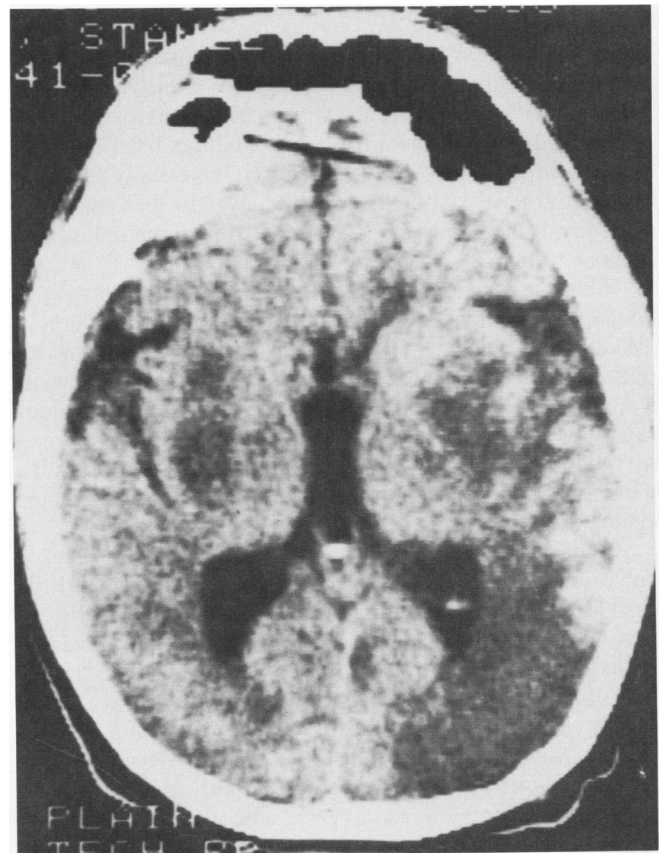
A final computed tomographic scan shows new low-density lesions bilaterally.
